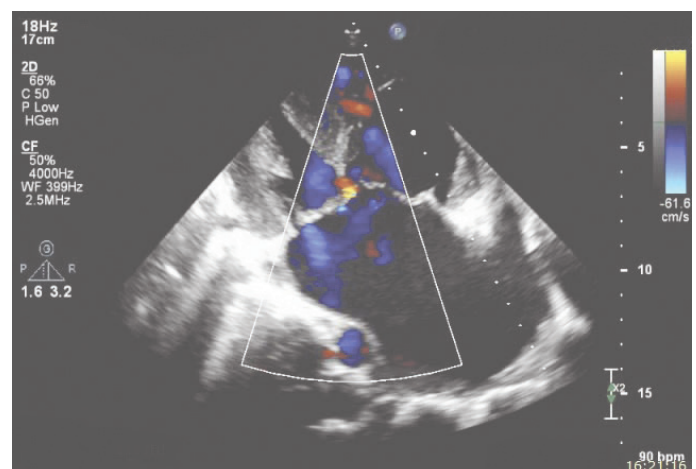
Two-dimensional apical four-chamber color Doppler image of atrioventricular (AV) valves
